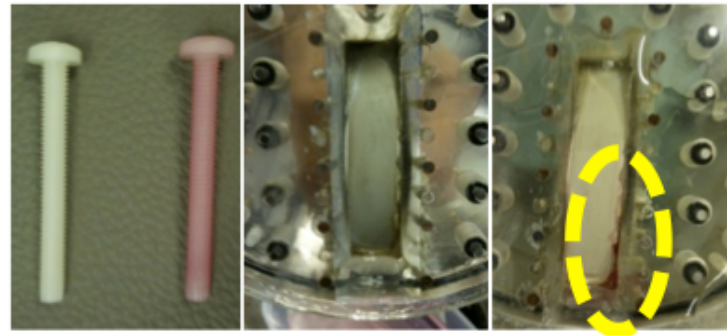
Discoloration from chlorexedine of nylon bolt (left); Ultrasound transducer glued to EIM plate with dual component resin (middle) and silicon addesive (right). Note, the resin has not been affected, the silicon addesive has.
